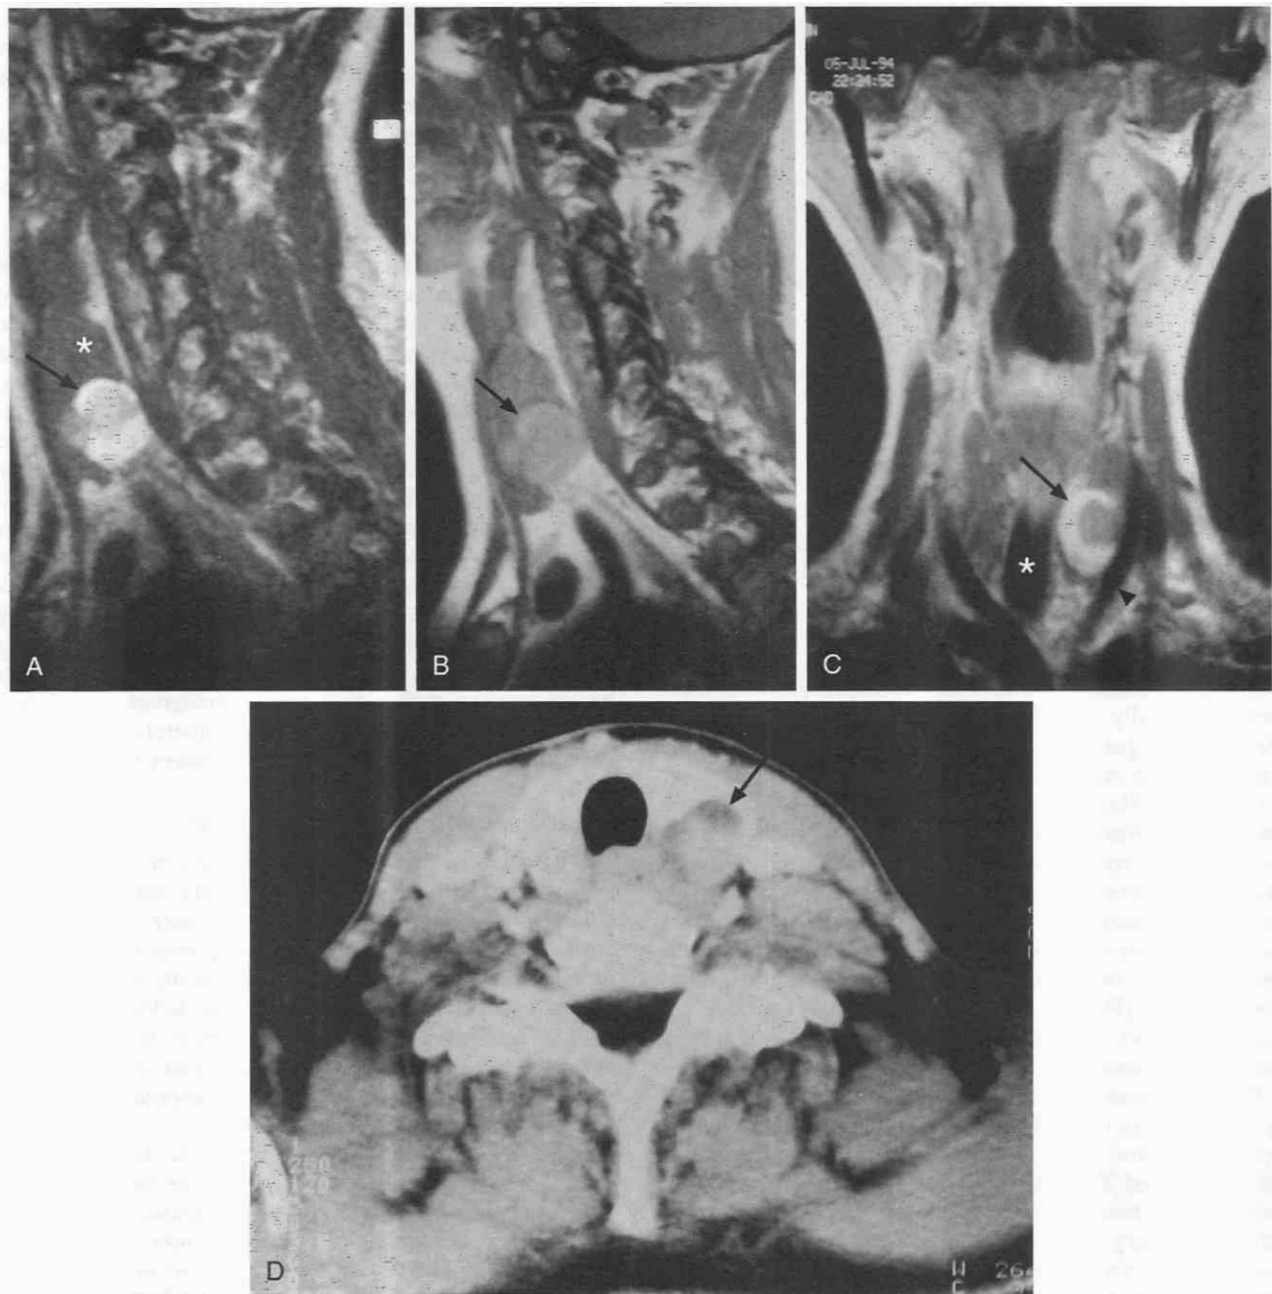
Follicular adenoma. *A*, Sagittal T2-weighted MR image demonstrates a mixed-signal-intensity ovoid mass (*arrow*) within the lower pole of the left thyroid gland. The lesion is peripherally hyperintense with a central nodule of intermediate signal. The normal thyroid parenchyma (*asterisk*) is homogeneously hypointense. *B*, Sagittal T1-weighted MR image shows the mass (*arrow*) to be of intermediate signal intensity but distinguishable from normal parenchyma. *C*, Coronal T1-weighted postgadolinium MR image shows enhancement of the peripheral component of the mass (*arrow*) with no appreciable enhancement of the central nodule. Note the relationship of the mass to the trachea (*asterisk*) and left common carotid artery (*arrowhead*). *D*, Axial postcontrast CT scan shows the well-circumscribed mass (*arrow*) in the posterior left thyroid lobe, with mixed attenuation. The imaging features of the nodule are nonspecific.
